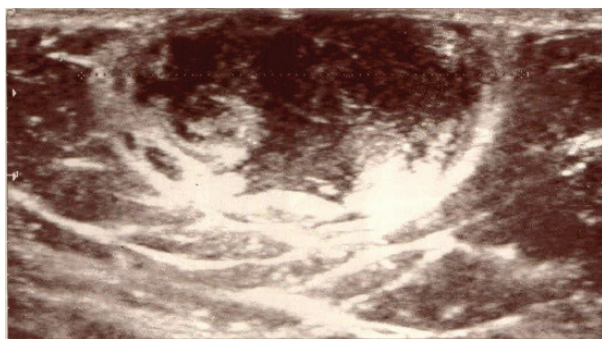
Gray-scale Sonography of the Right Breast and Axilla Showed a Well-Defined $31 \times 22 \times 19$ mm Cyst With Thick Wall, Suggestive of a Complex Cyst or Infected Epidermal Inclusion Cyst
